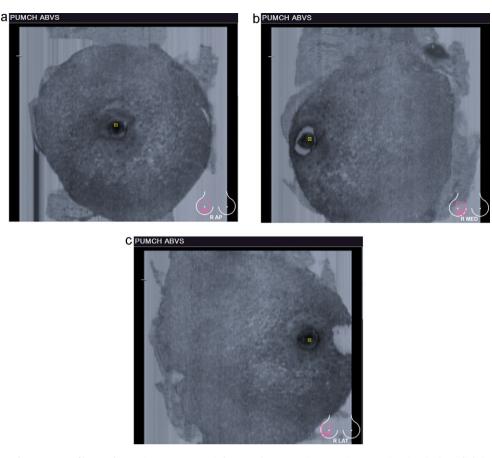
The regular ultrasound appearance of human breast tissue on automatic breast volume scanning: anterior-posterior view (AP), medial view (MED) and lateral view (LAT).
